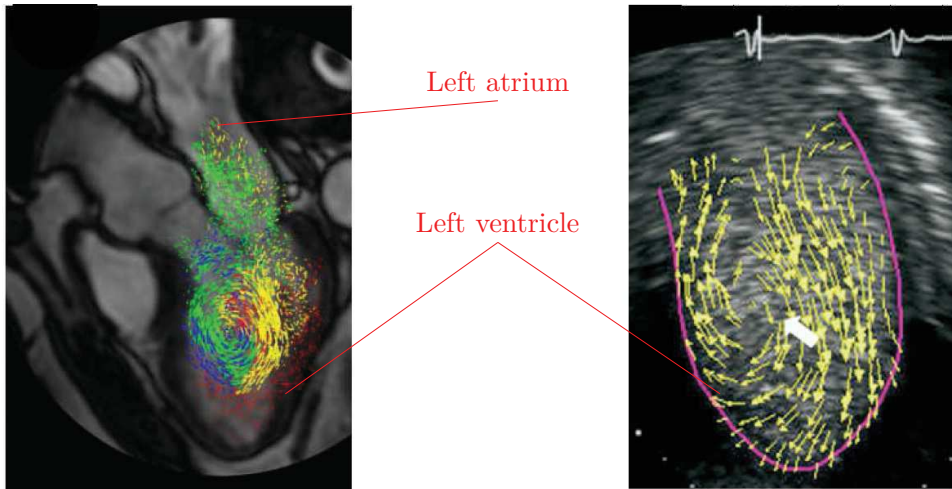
Visualization of blood flow in a left heart. (a) Phase-contrast magnetic resonance imaging (from [109]) and (b) Echo-PIV (from [84]).
